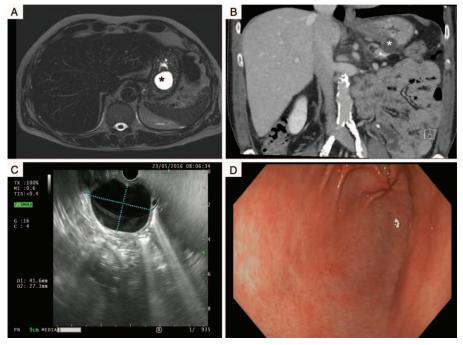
Patient # 1—Intramural gastric pseudocyst, (A) MRI with axial T2 shows a high signal in a well-circumscribed pseudocyst. (B) Coronal CT of the abdomen with intravenous contrast shows the intramural pseudocyst embedded into the stomach wall. (C) EUS shows the clear fluid content of the pseudocyst. The cyst appears to be located in the submucosal layer of the gastric wall. (D) Gastroscopy shows normal smooth mucosa found over the pseudocyst area. The pseudocyst is indicated with an*. CT=computer tomography, EUS=endoscopic ultrasound examination, MRI=magnetic resonance imaging.
